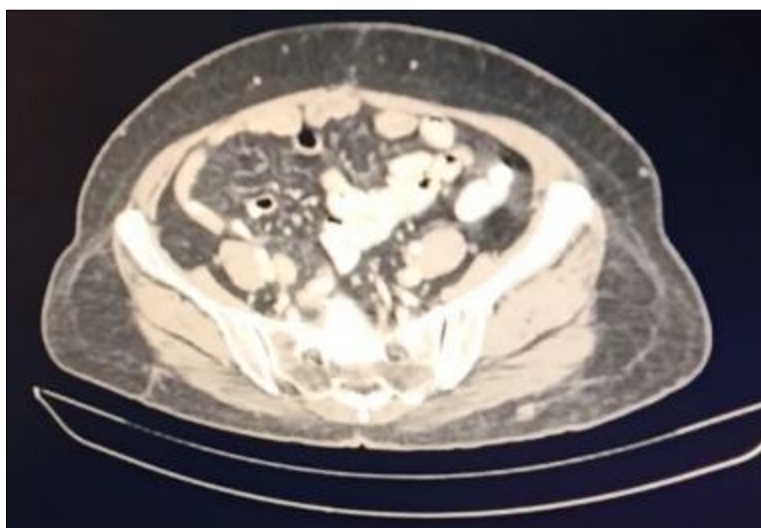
CT (Abdomen +Pelvis) scan - showing partial response after starting Bevacizumab
